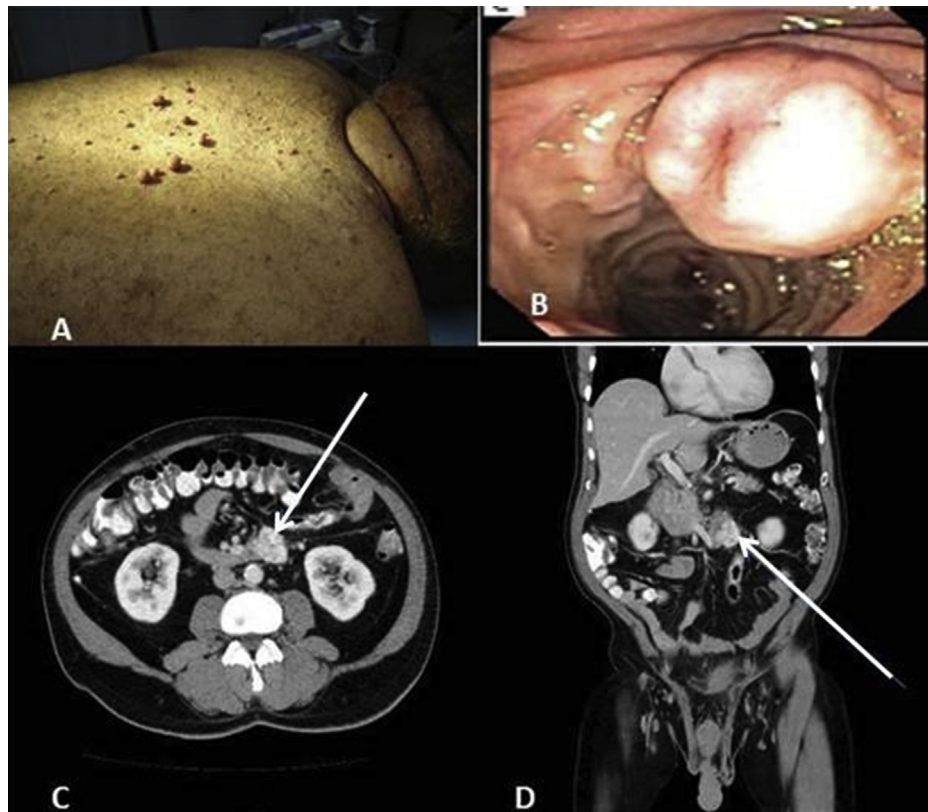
68 year old male with neurofibromatosis (A), diagnosed with large GIST of the duodenum on endoscopy (B), CT scan showing locally advanced GIST (arrows) with extramural extension (C, D).
